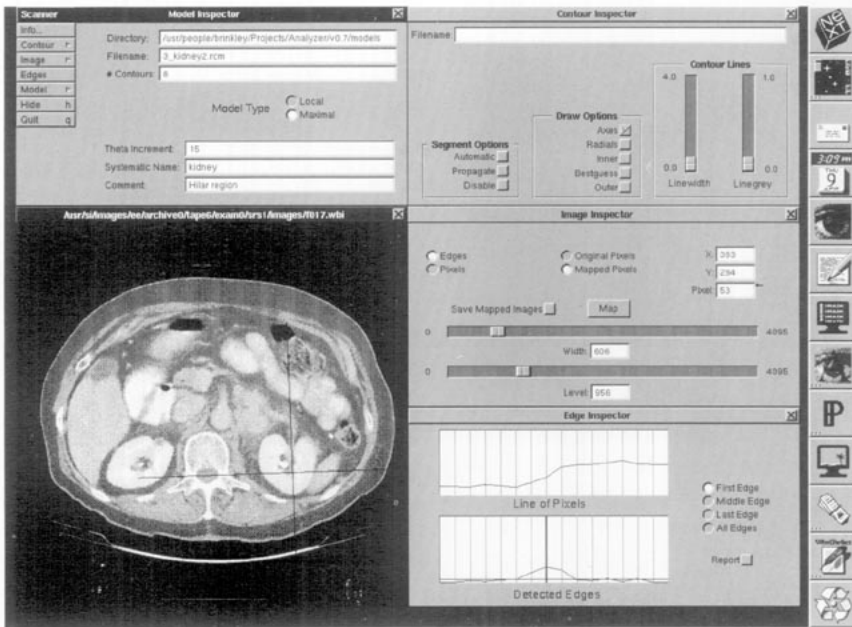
SCANNER user interface. The user controls the operation of the program through menus (not shown) and panels corresponding to the major data structures: models, contours, images, and edges. The image at the lower left is an abdominal CT image through a kidney. The crossed lines are a user-defined local coordinate system for the radial contour model 3_kidney2.rcm that will be used to find the kidney in Fig. 3.
